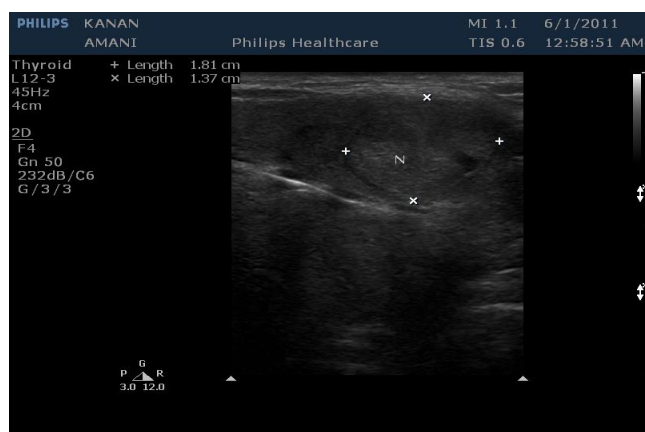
Longitudinal sonogram of a typical hypoechoic, well-defined, round lesion with a thyroid adenoma
